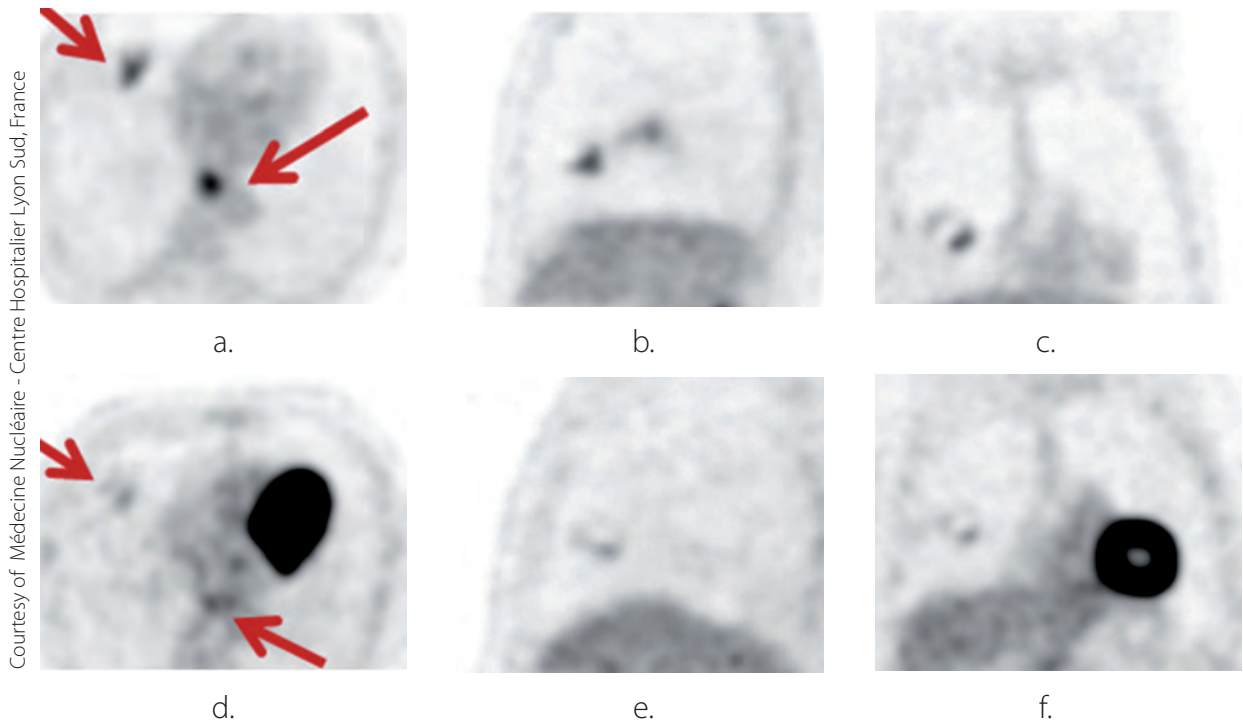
Response assessment with  $^{18}\text{F}$ -FDG: axial  $^{18}\text{F}$ -FDG PET views (a,d), sagittal  $^{18}\text{F}$ -FDG PET views (b,e) and coronal  $^{18}\text{F}$ -FDG PET views (c,f) in a stage IIIb NSCLC (red arrows: primary tumour and mediastinal lymph node) before (a–c) and after (d–f) radiochemotherapy (good response with lower intensity metabolism)
